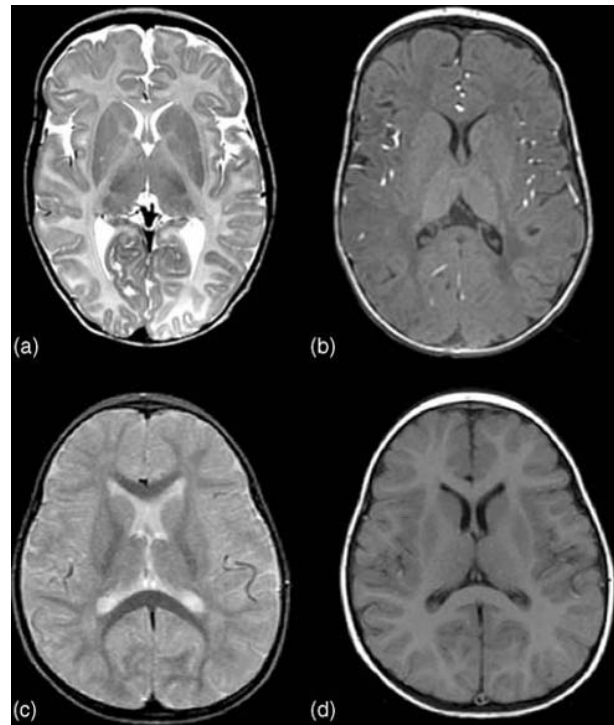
(A) T2w and (B) T1w axial MRI images of a 12-month-old boy with the congenital form of Pelizaeus–Merzbacher disease and a missense mutation in *PLP1*. Myelination is lacking completely in the T2w image and almost completely in the T1w image. For comparison, respective T2w and T1w MRI images of a healthy 12-month-old child (C + D).
